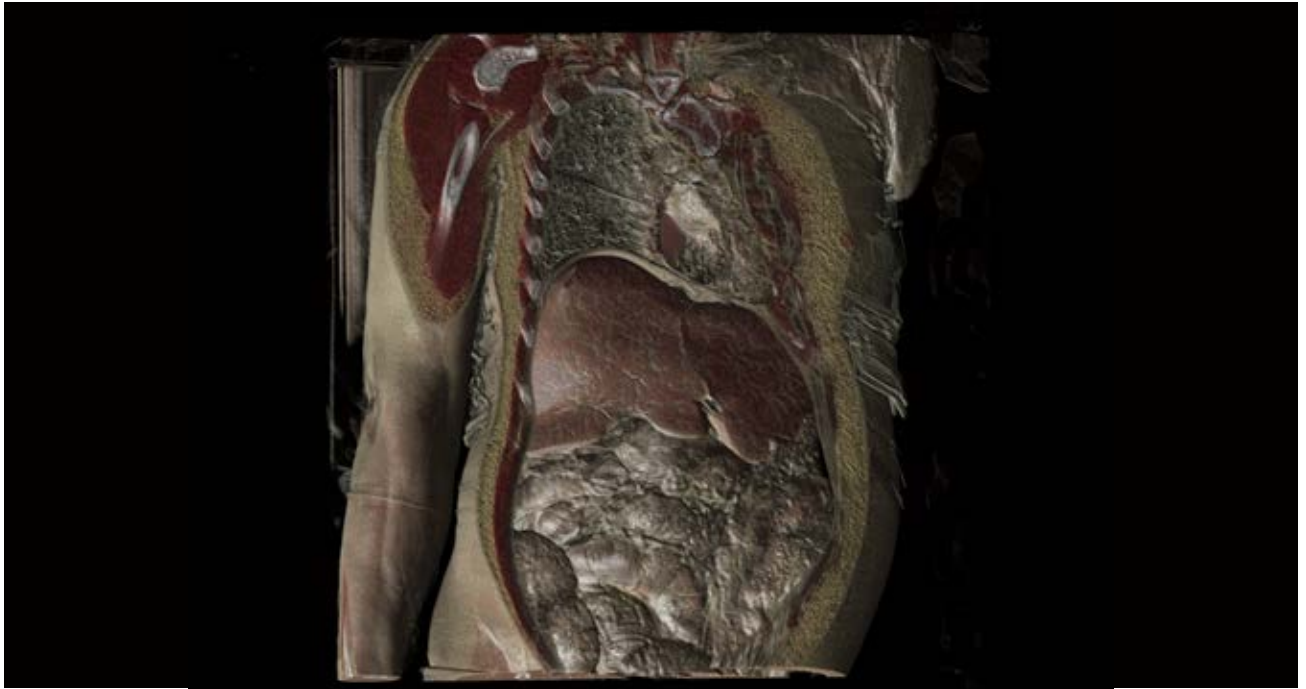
Postmortem Dual Energy computed tomography of a deceased person. Soft tissue rendered with different colours and different translucencies. Part of the anterior tissue virtually removed from the body so that the underlying organs can be studied.
